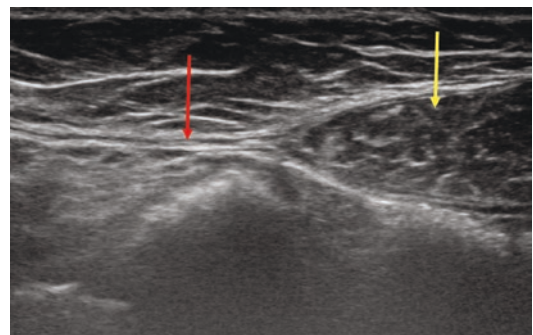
Ultrasound is a frequently used imaging modality and is able to easily demonstrate the hypoechoic rectus abdominis muscle belly (yellow arrow) and the hyperechoic fascia of the linea alba (red arrow). Note the medial confluence of the anterior and posterior rectus sheaths in the midline which form the linea alba. The inter-rectus distance in this patient is widened (medial edge of the contralateral rectus muscle is not visible)
